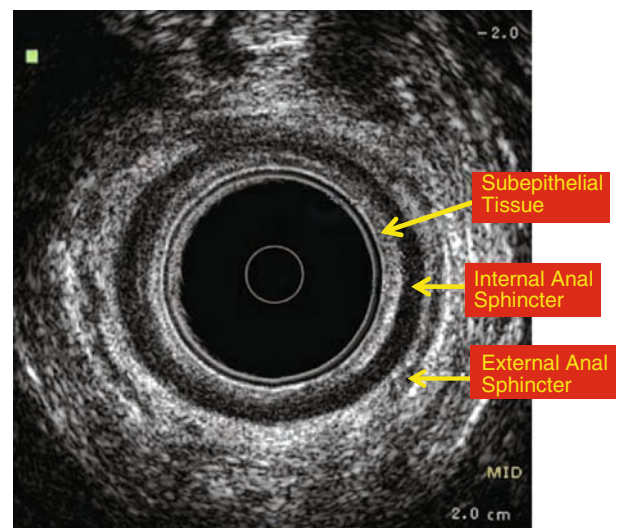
Mid anal canal. Normal mid-anal canal as it appears on endorectal ultrasound. Hallmarks of the mid-anal canal are the internal and external anal sphincters
